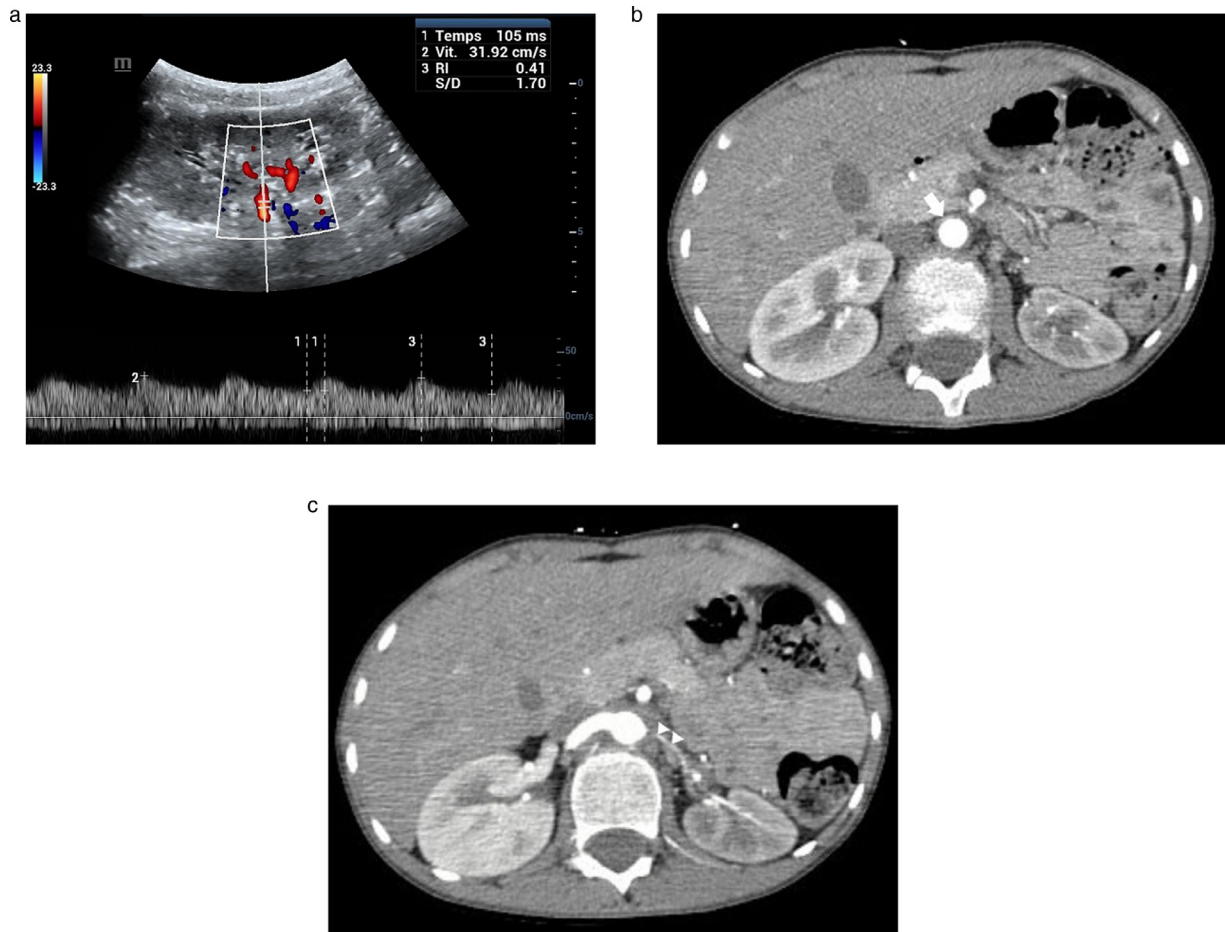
Renal Doppler examination revealing a low resistance index (0.41) with flattened arterial curves in the distal portion of the left renal and interlobar arteries (A), suggestive for renal artery stenosis. Multiphase CT scan of the renal tract demonstrating concentric mural thickening (arrow) of the abdominal aorta (B) and the proximal portion of the left renal artery (arrow heads) causing its tight stenosis (C).
